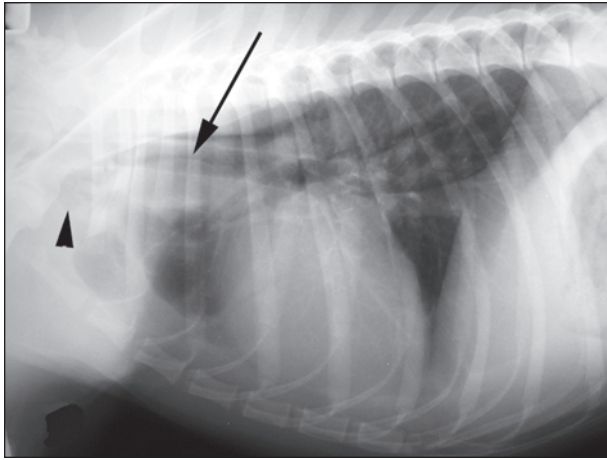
Same right lateral radiographic view as in Figure 1. Notice the pneumomediastinum enhancing visualization of the brachiocephalic trunk (arrow) and gas within the fascial planes at the level of the thoracic inlet (arrowhead) and a minimal amount of pleural effusion.
